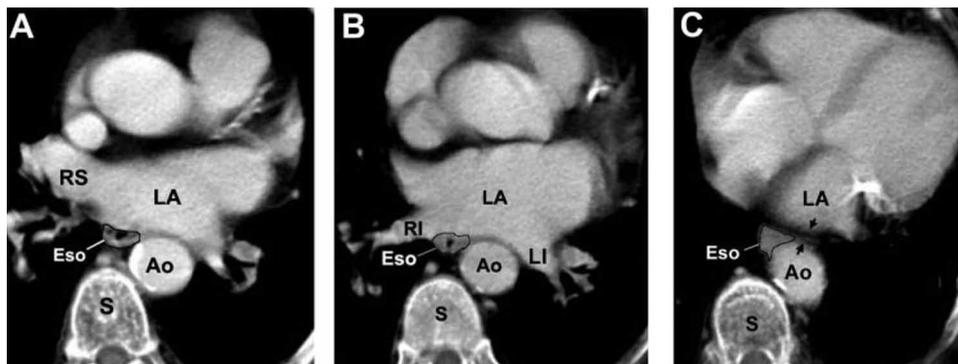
Axial CT images of a patient with a type 2 esophageal route (the distance to the RIPV is shorter than that to the LIPV). *Left, A:* At the RSPV level, the location of the esophagus (enhanced border) is behind the LA and RSPV, in front of the thoracic spine, and medial to the descending aorta. *Center, B:* At the RIPV level, the esophagus is very close to the RIPV ostium. Thus, the potential risk for the development of an atrioesophageal fistula is higher during ablation around the RIPV ostium than around the LIPV ostium. *Right, C:* At a level below the RIPV, in contrast to the tight contact between the esophagus and LA (in *left, A,* and *center, B,*) a fat pad (between the two arrows) between the posterior LA and esophagus is observed. See Figures 2, 3 for expansion of abbreviations.
